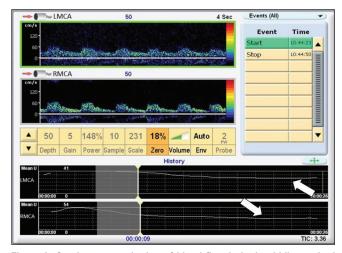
Continuous monitoring of blood flow in both middle cerebral arteries with transcranial Doppler during the hypercapnic challenge shows paradoxical reduction of flow velocities (arrows)
